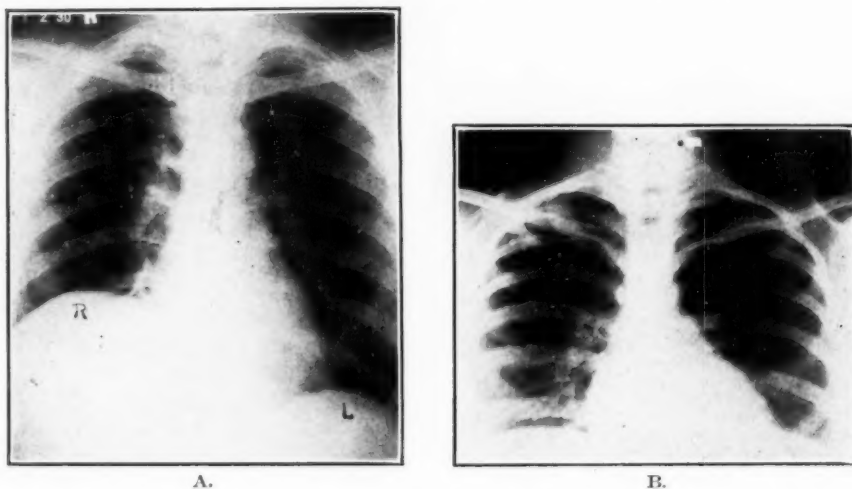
A, X-ray of a young woman, aged twenty-two, two months pregnant, showing early pulmonary tuberculosis at second right interspace. B, The same patient one week before normal labor, showing the tuberculous lesion healed. The elevation of the diaphragm here is due to pressure upward of the increased abdominal contents.
